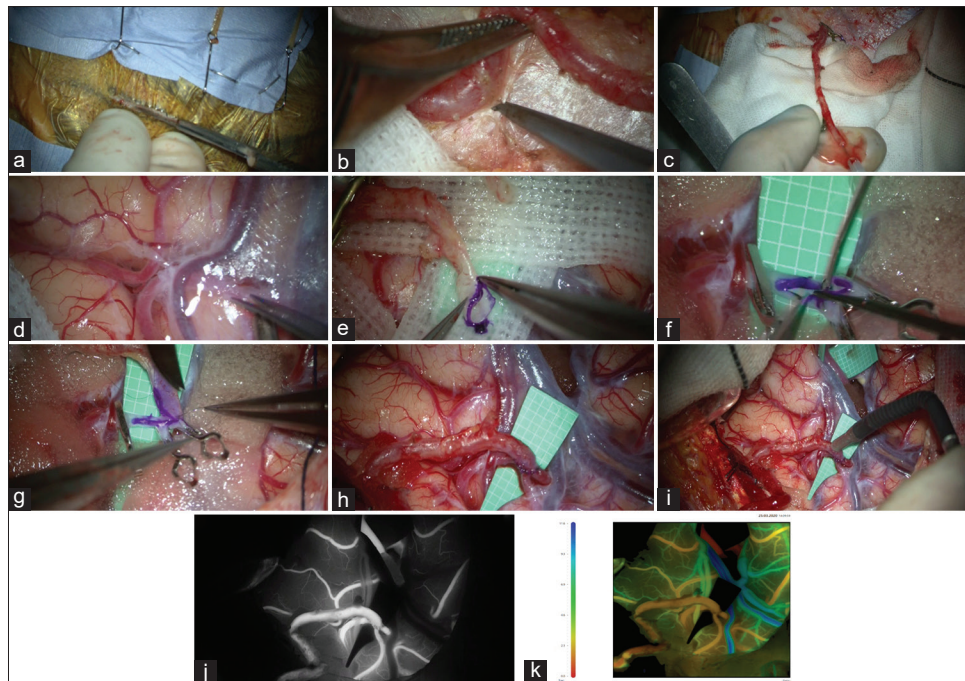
Superficial temporal artery-M3 anastomosis (a) Scalp incision; (b) Harvesting superficial temporal artery; (c) Harvested anterior branch of the superficial temporal artery with the main trunk; (d) Sylvian fissure dissection; (e) Preparation of donor end of the superficial temporal artery for anastomosis; (f) Left middle cerebral artery M3 arteriotomy; (g and h) superficial temporal artery-M3 end to side anastomosis; (i) Checking flow using micro-Doppler; (j) indocyanide green showing good superficial temporal artery-M3 blood flow; (k) Postsuperficial temporal artery-M3 bypass FLOW 800 analysis demonstrates yellow color indicating good artery blood flow
